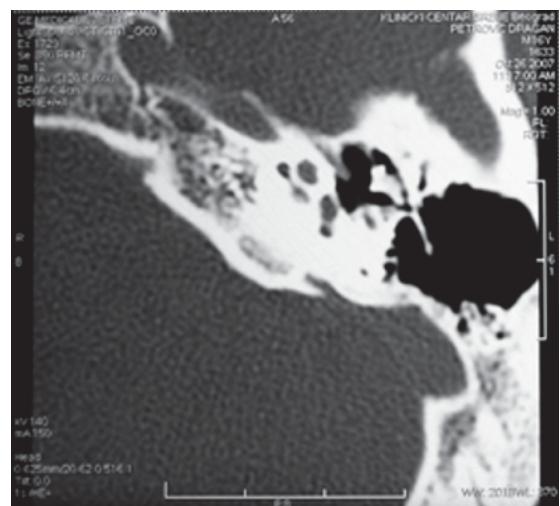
Coronal temporal bone computed tomography (CT) shows removal of mastoid cells, normal position of a ventilation tube and intact middle ear cavity
